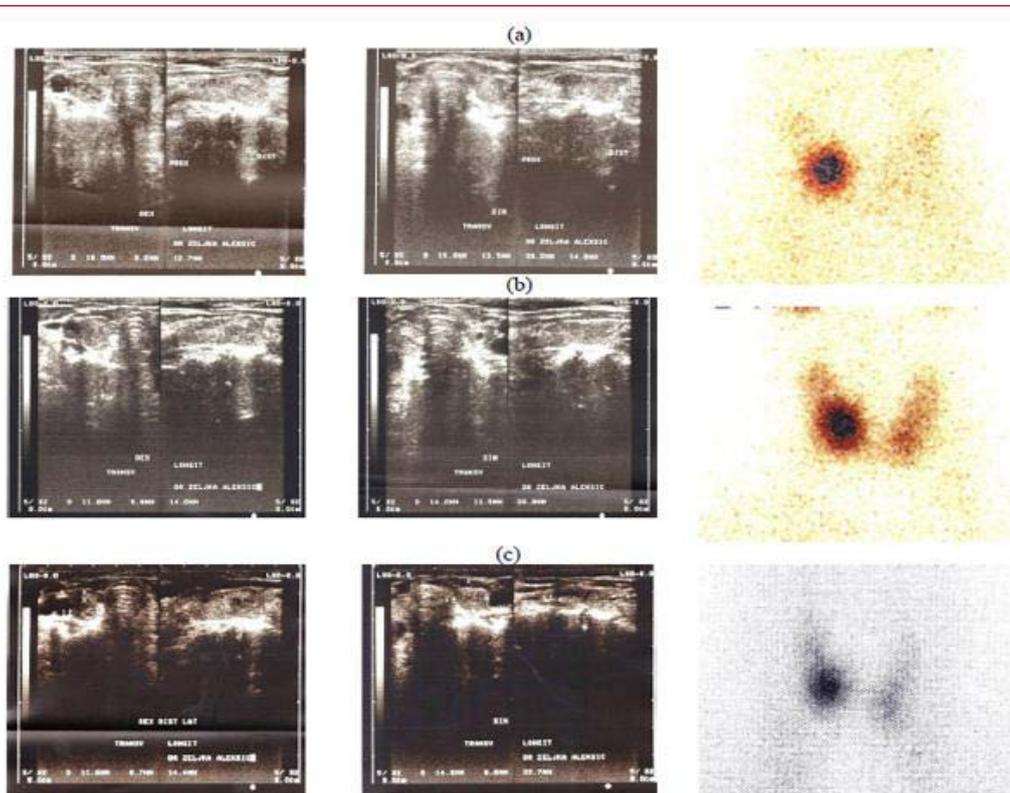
Echosonographic findings and pertechnetate thyroid scan in a patient during follow-up (a) the 1st visit. (b) Four months after 1st visit. (c) One year after 1st visit.
